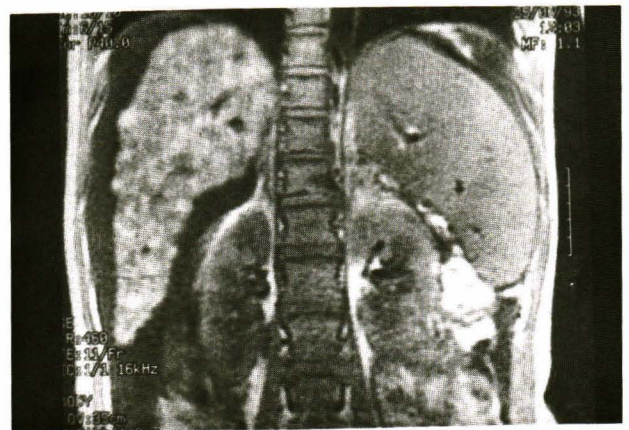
Coronal T1 weighted MRI show small liver with multiple regenerated nodules, splenomegaly and ascites.
